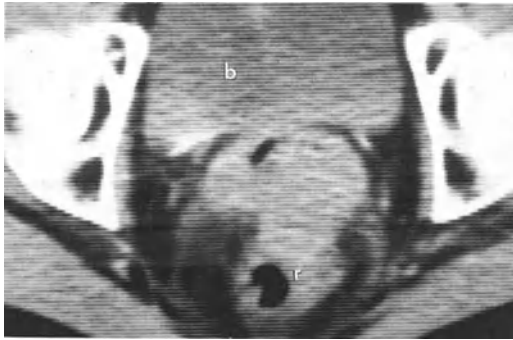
CT: carcinoma of cervix stage IVb. Bulky tumor mass of the cervix with small necrosis. Broad infiltration of the rectum (*r*). Tumor extension also towards the bladder (*b*), reaching its dorsal wall. Whether there is already infiltration or not must be clarified with cystoscopy and biopsy
